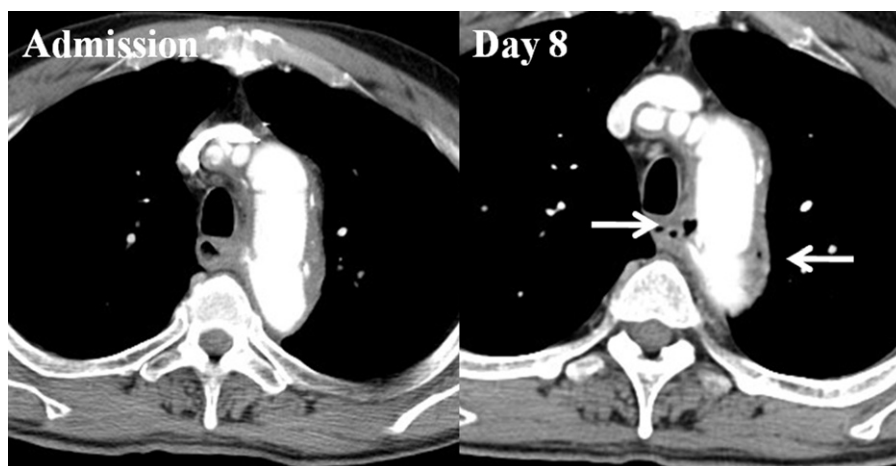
First contrast-enhanced computed tomography (CT) scan performed on admission did not have abnormal findings except postoperative fluid retention and second contrast-enhanced CT scan performed on day 8 revealed ectopic gas around the graft (arrow) suggesting a prosthetic graft infection.
